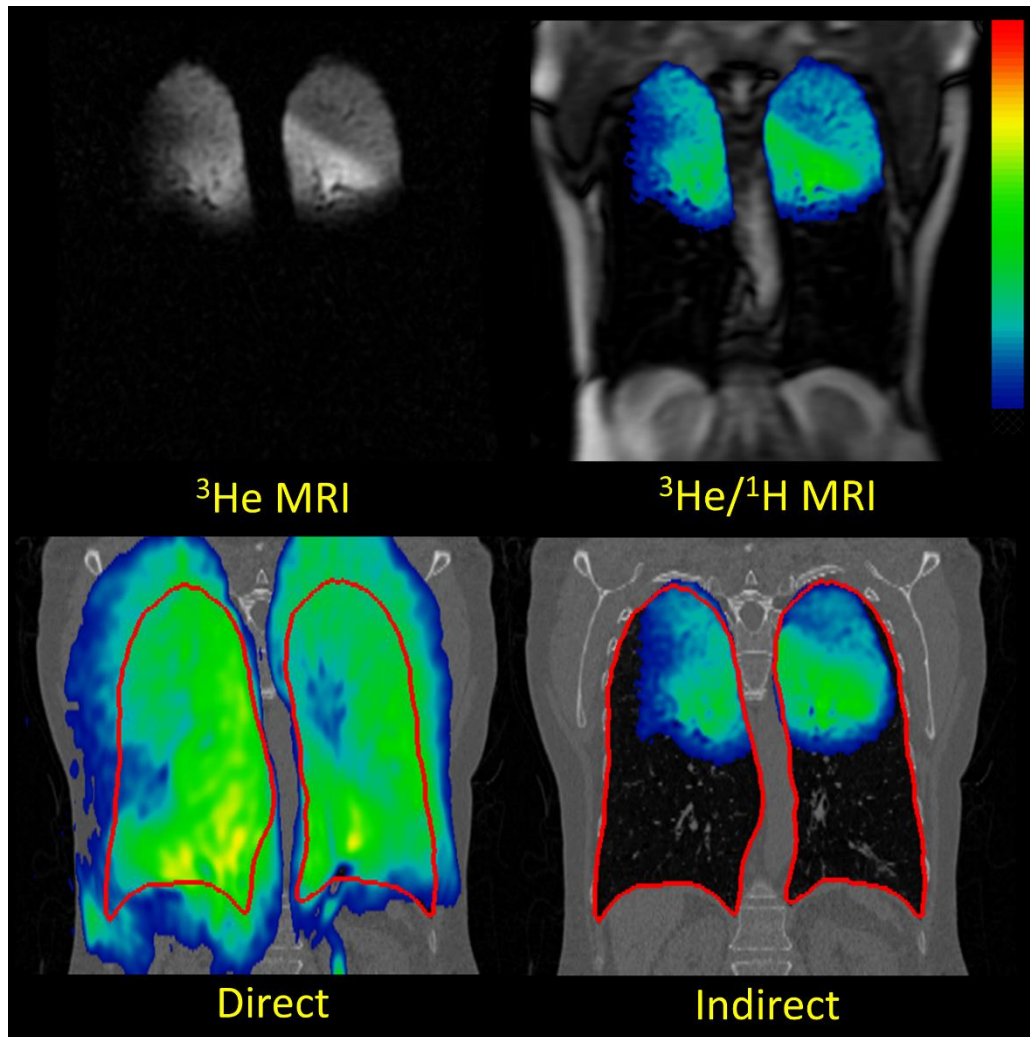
Corresponding coronal slices of patient 9 showing registered ^3He MRI fused with CT via the direct (bottom left) and indirect (bottom right) diffeomorphic methods with preregistered ^3He MRI (top left) and ^1H MRI fused with ^3He MRI (top right). The direct method breaks down, attempting to stretch the ^3He images which show ventilation in the upper lobes only, across the whole lung.
